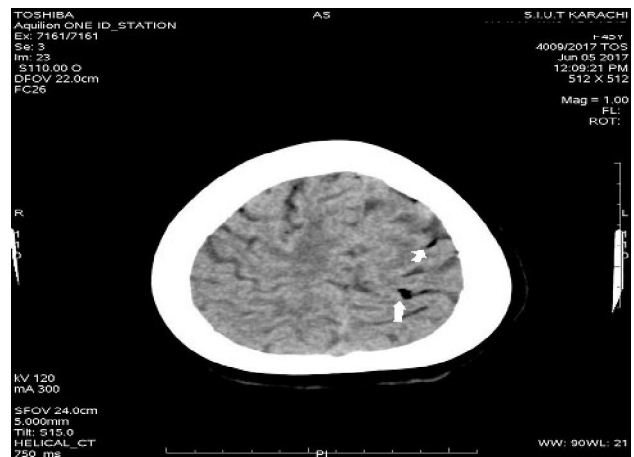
Non-Contrast axial CT Brain shows air bubbles (arrows) in the bilateral cerebral hemisphere
